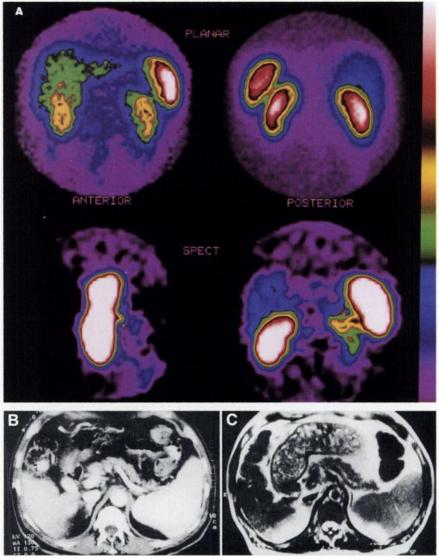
SRS of patient 5. (A) Abdominal planar scans (top, anterior and posterior views) show no abnormal uptake, whereas SPECT images (bottom, sagittal slice on left and coronal slice on right) localize 1 focus (arrow) between spleen and upper pole of left kidney. CT scan (B) and MR image (C) show no tumor site. One week after scintigraphy, surgery revealed insulinoma in pancreatic tail.
